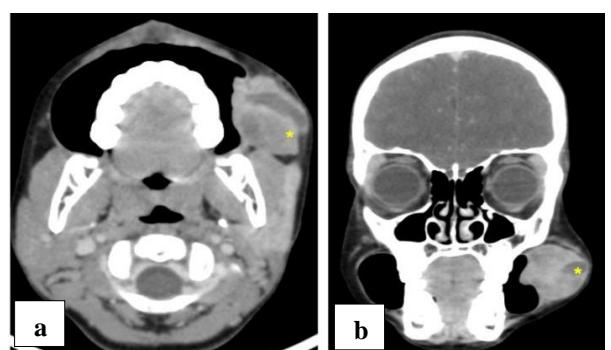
(a) Axial and (b) coronal contrast enhanced CT with puffed cheek manoeuvre shows a well-defined heterogeneously enhancing lesion (asterisk) in the left cheek and buccal mucosa-buccinator complex.
